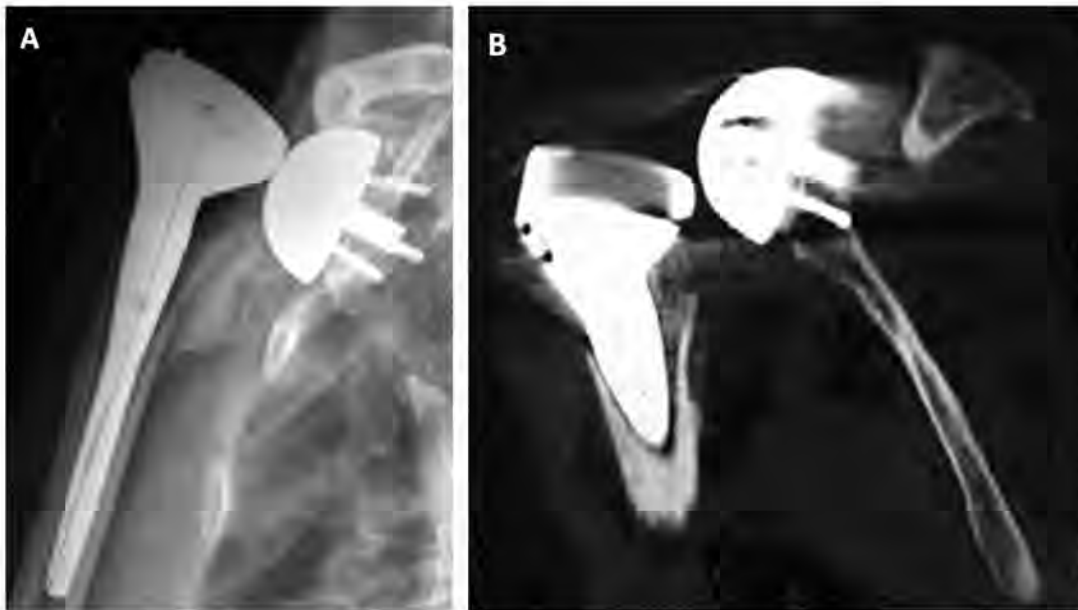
Recurrent instability because of (1) humeral shortening, (2) medialization and superior orientation of the glenoid, and (3) medial cam effect by medial humeral ossification. A. Radiograph. B. CT.
